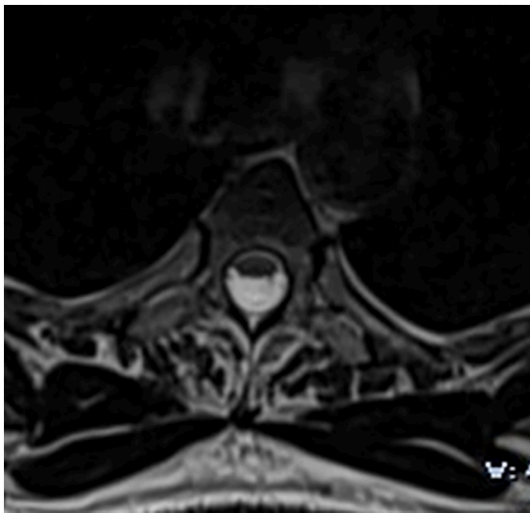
Axial section of a thoracic spinal cord MRI on T2-WI at the level of T8 showing an enlarged posterior subarachnoid space associated to an anteriorly compressed spinal cord.
